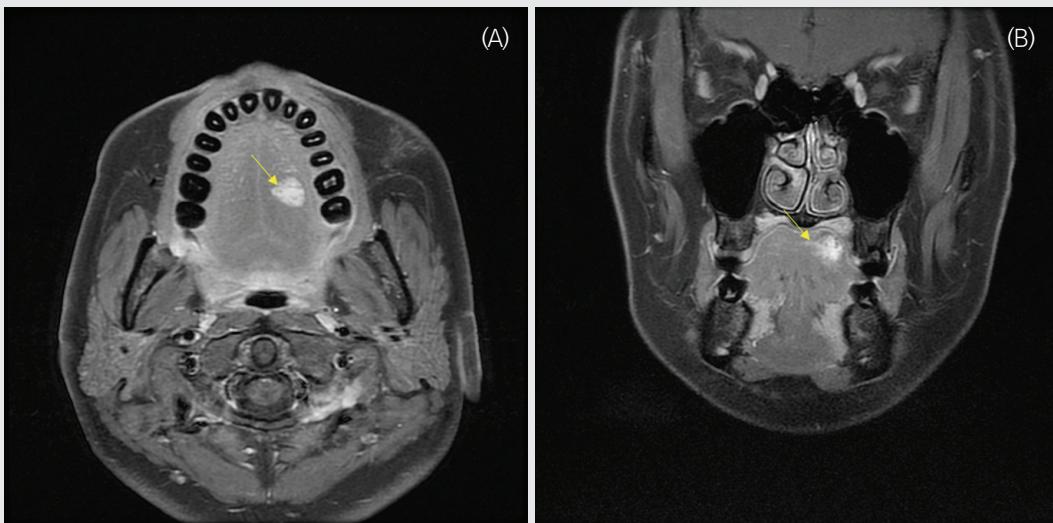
Contrast-enhanced CT scan image demonstrates a vascular malformation on left tongue dorsal surface. (arrow)
